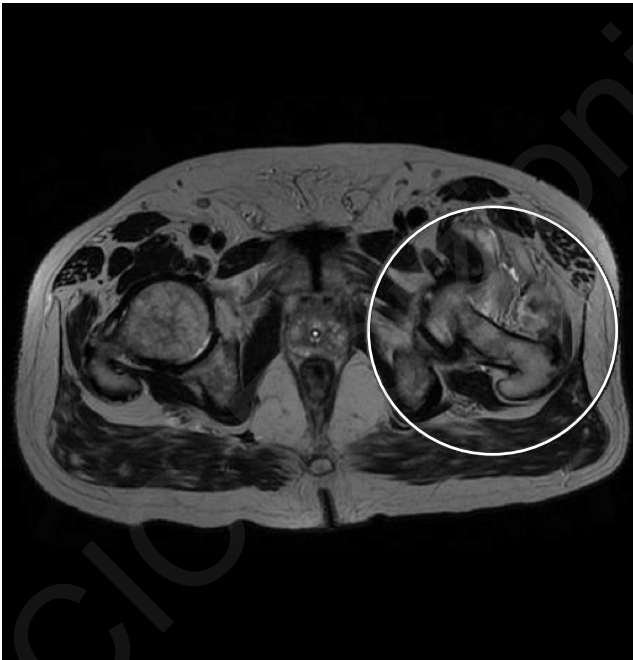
Stick appearance of femoral neck on MRI. T2 weighted images.
